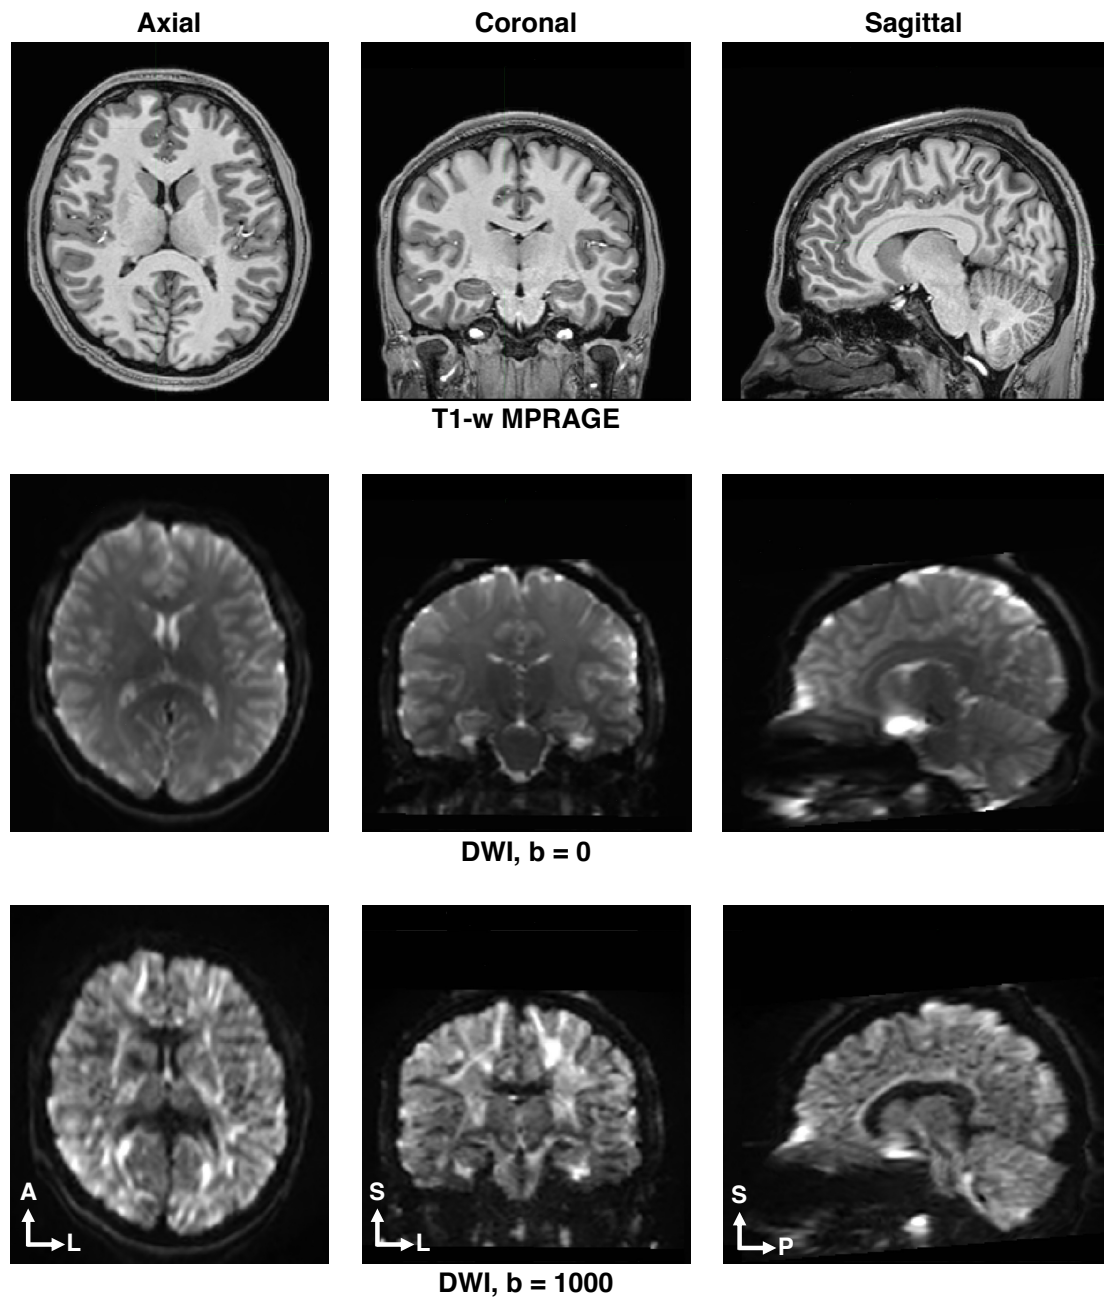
Examples of different MRI modalities of the same subject at the brain.
